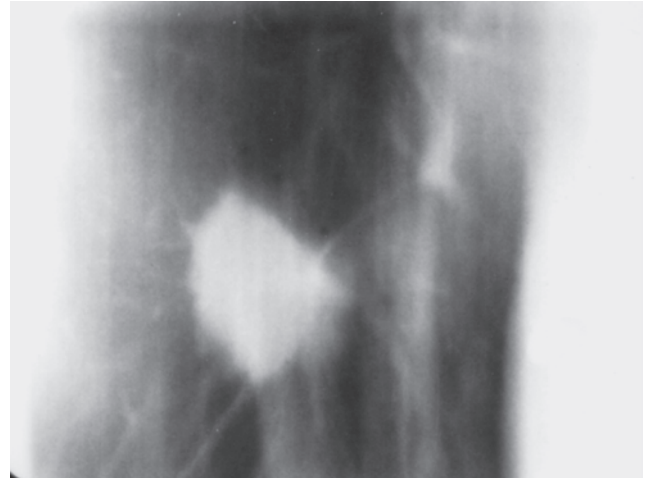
Tomography of a solitary nodule showing spiculation, or sunburst effect, characteristic of primary bronchogenic carcinoma. Spicules represent extension of the tumor into septa. CT showed a similar appearance.
